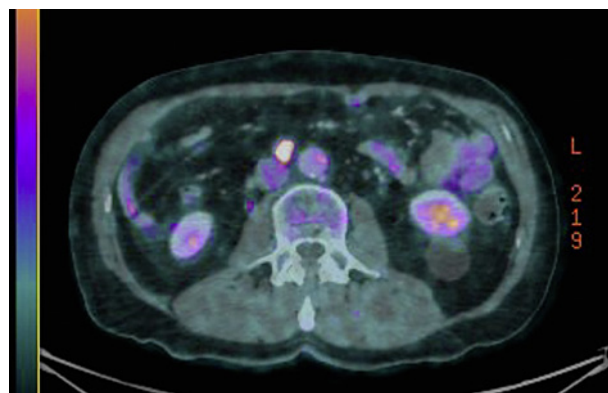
PET-CT (February 2022) demonstrating a >1 cm fluorodeoxyglucose (FDG) avid lymph node consistent with metastatic disease.
